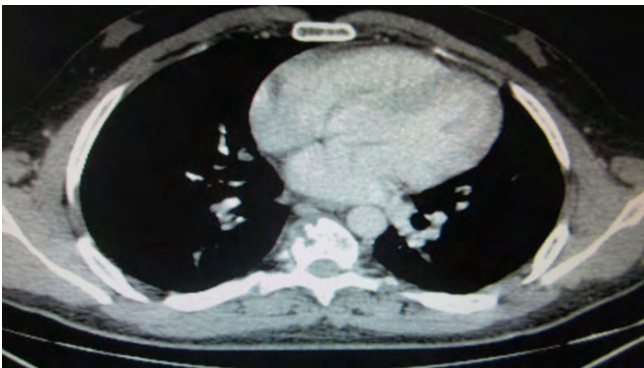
Thorax CT- Vertebrae lytic lesion
